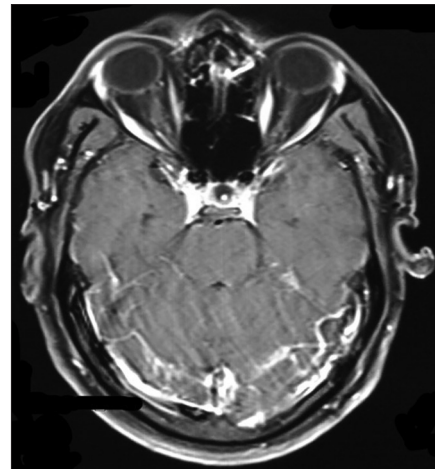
MRI showing orbital apex region
